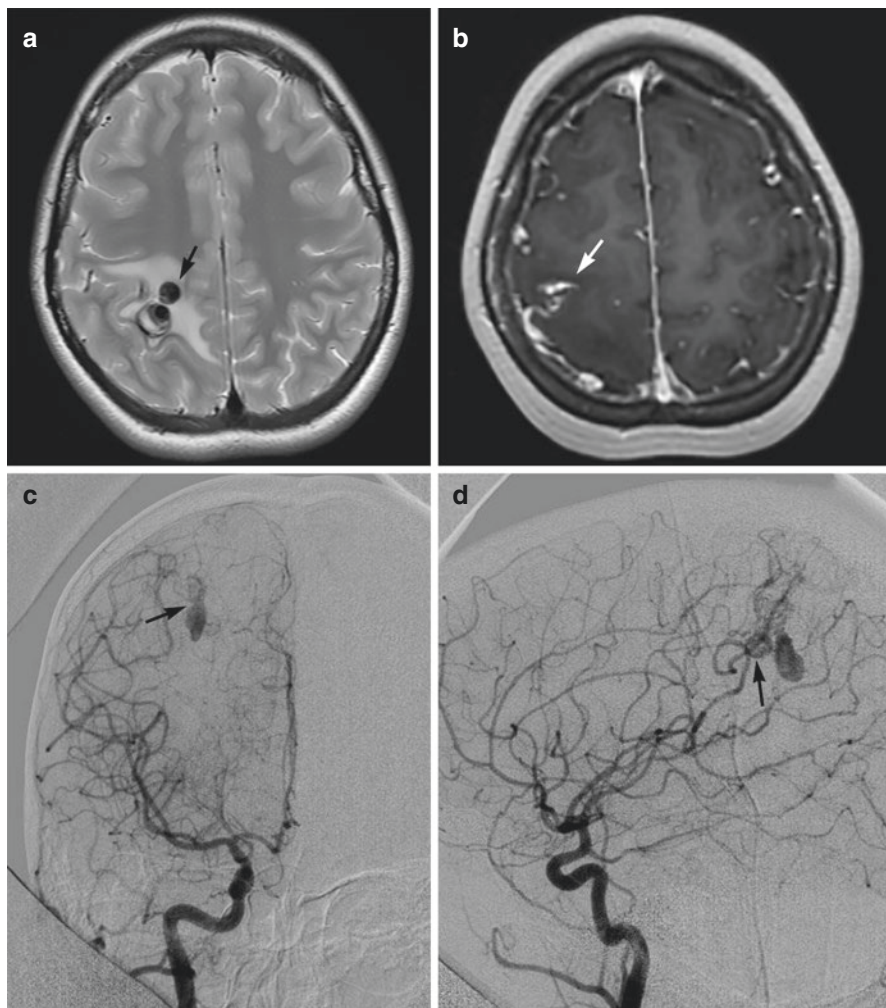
A 16-year-old female patient presented with seizures, and imaging demonstrated a Spetzler-Martin grade II arteriovenous malformation (AVM). She underwent preoperative embolization followed by craniotomy for resection. (a) T2-weighted axial magnetic resonance imaging (MRI) demonstrates large venous dilatations, secondary to an AVM, with surrounding cerebral edema (*arrow*). (b) Gadolinium-enhanced axial MRI demonstrates superficial cortical drainage of the AVM (*arrow*). (c–d) Preoperative digital subtraction angiography with a right internal carotid artery injection demonstrates the AVM with superficial drainage (*arrow*). (e–f) Postoperative digital subtraction angiography of the right internal carotid artery injection demonstrates obliteration of the AVM with no evidence of early venous drainage (Used with permission from Barrow Neurological Institute, Phoenix, Arizona)
